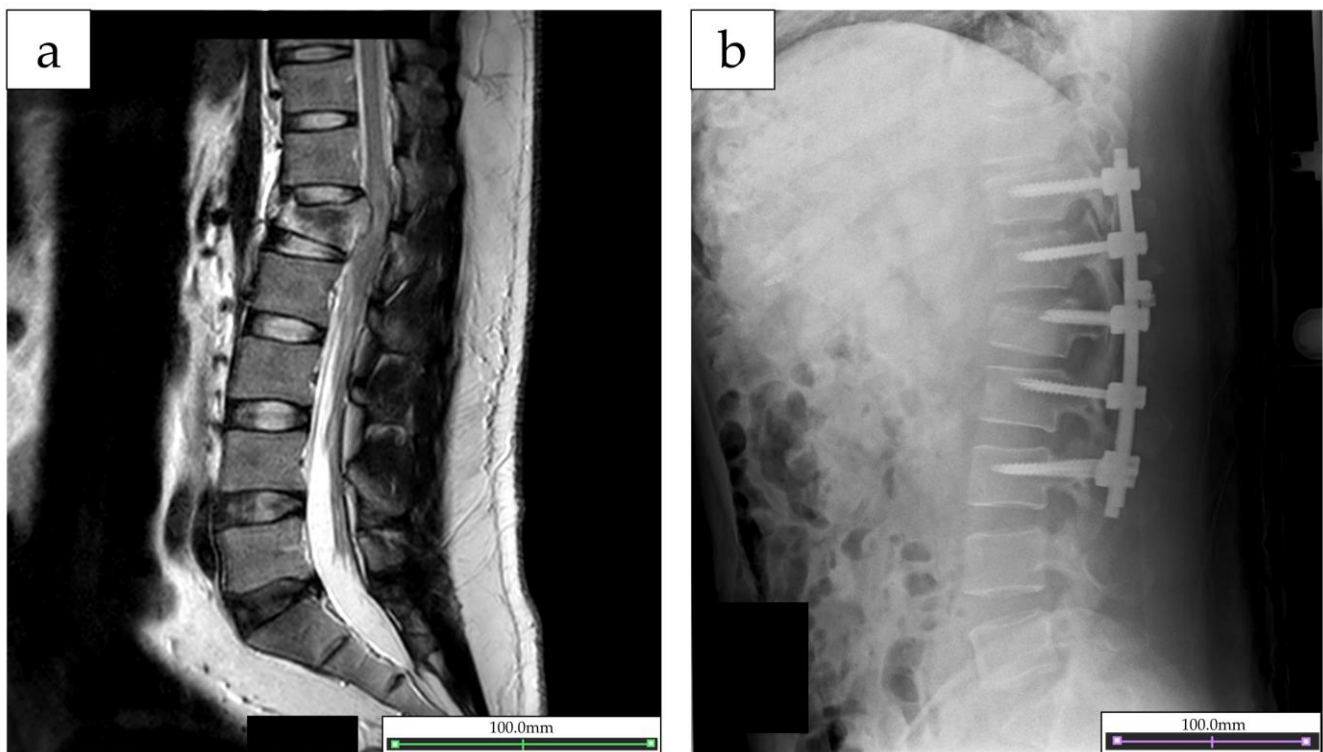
(a) Magnetic resonance imaging images of the lumbar spine and spinal cord taken on the date of injury. (b) X-ray image after posterior spinal decompression fusion.
